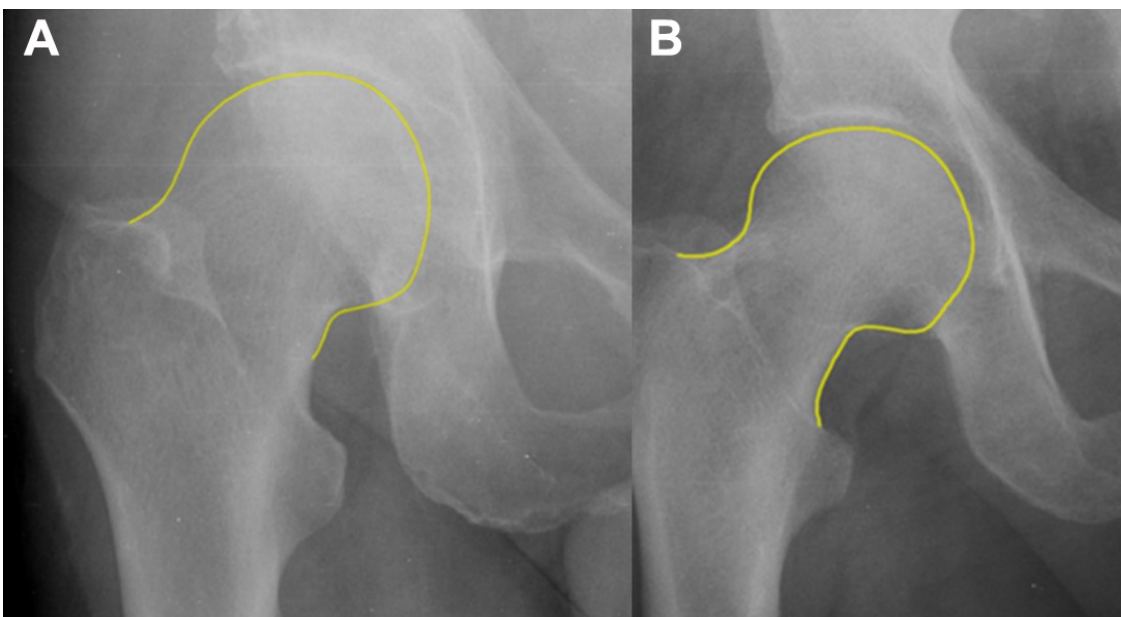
Positive (A) and negative (B) pistol-grip deformity on anteroposterior hip radiographs
